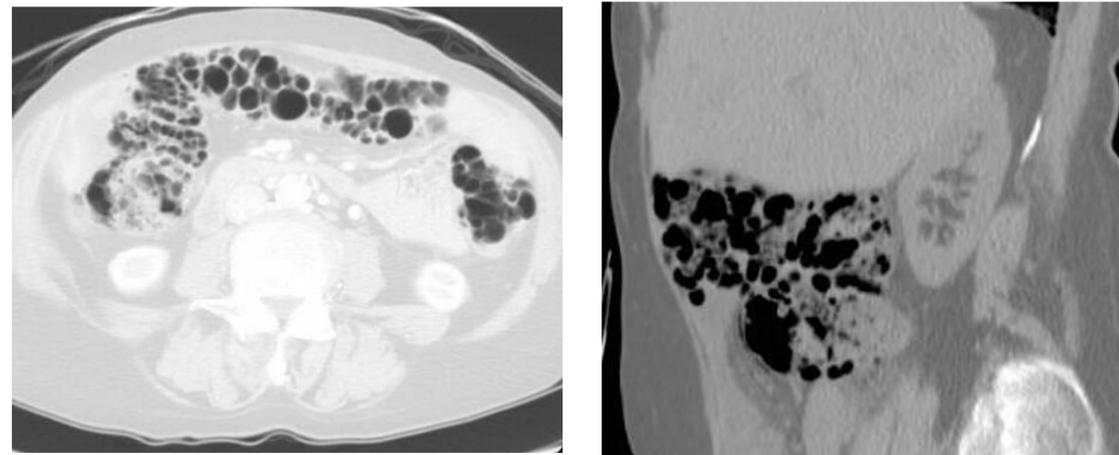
Axial (left) and sagittal (right) images from a contrast-enhanced CT demonstrate cystic lucencies throughout the transverse colon.
